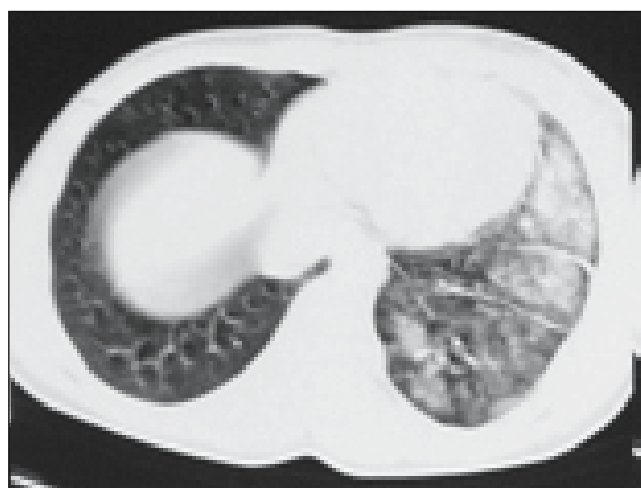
Bilateral contusion of the same patient seen on CT.
